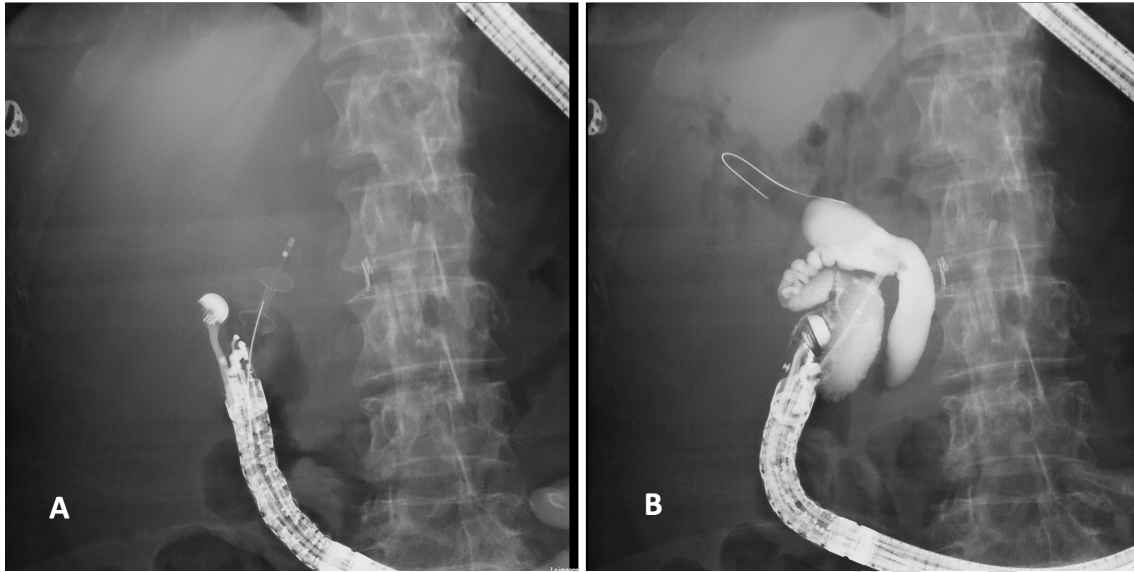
A. This X-ray image displays the lumen-apposing metallic stent (LAMS) immediately after deployment in an EUS-guided choledochoduodenostomy procedure. B. Subsequent cholangiography through the LAMS confirmed the patency of the bile duct, demonstrating absence of leakage.
